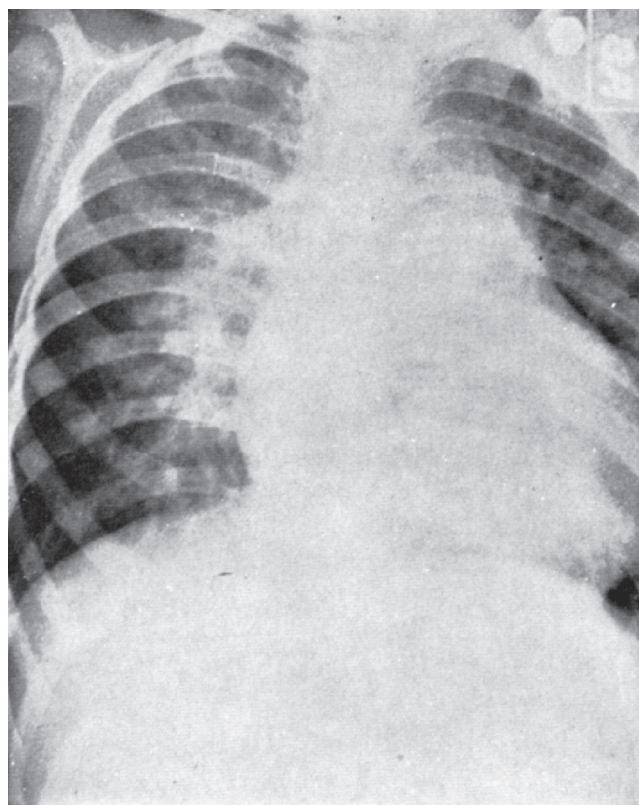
■ Chest radiograph of a child with a large ventricular septal defect, large pulmonary blood flow, and pulmonary hypertension, but only mildly elevated pulmonary vascular resistance, as indicated by left and right ventricular enlargement, enlargement of the main pulmonary artery, and a sharp increase in pulmonary vascular pattern.
